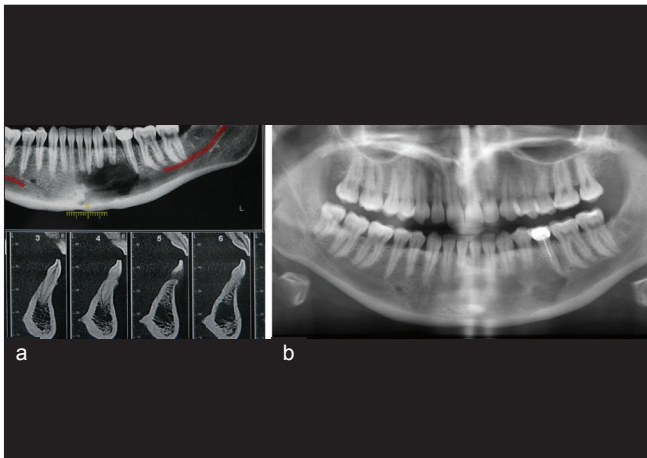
Radiographs of a biopsy-proven central giant cell granuloma of the left anterior mandible in a 23-year-old female (a) represents the lesion at the time of biopsy and (b) represents the lesion some 18 months later. No other surgical treatment than the biopsy was performed. Note that the lesion is almost completely resolved
